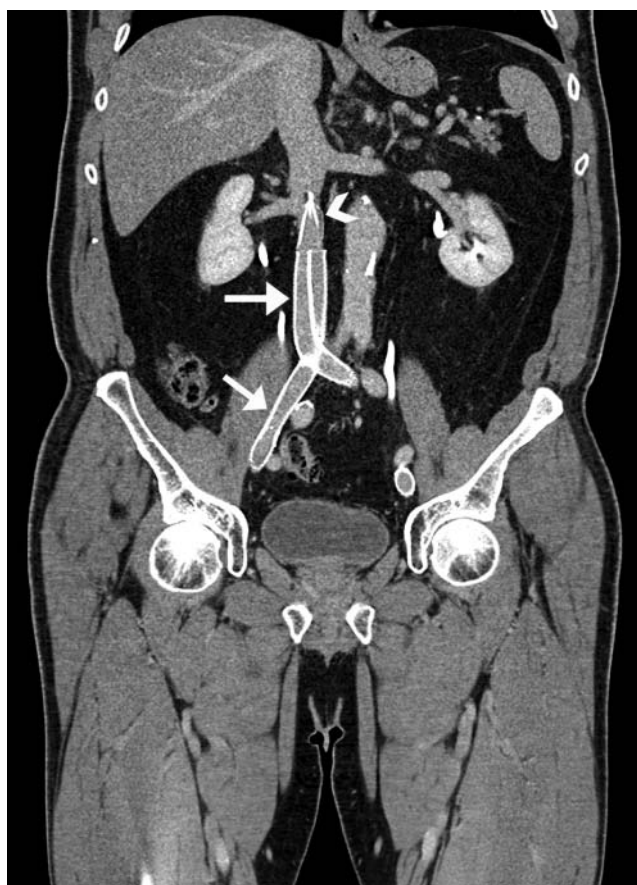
A 45-year-old male presented with bilateral lower limb swelling and tenderness. Duplex ultrasonography diagnosed bilateral deep vein thrombosis extending above the inguinal ligaments. Because of the severity of limb symptoms, catheter-directed lysis was initiated, with a safety retrievable caval filter also inserted. On check venography, cavoileal stenosis was unmasked. A coronal computed tomographic scan acquired during the portovenous phase following iodinated contrast administration demonstrates the postprocedure result. There are bilateral kissing cavoileal stents in situ (*arrows*), along with the caval filter (*arrowhead*). Note that the thrombus has completely cleared following lysis.
